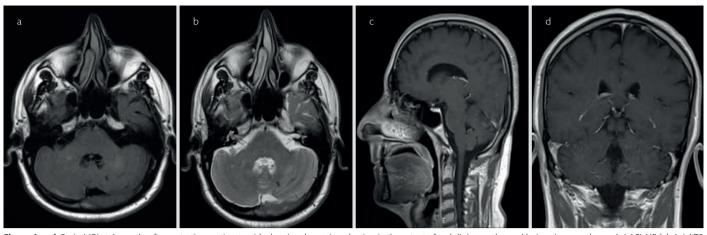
a-d. Brain MRI at 4 months after restarting corticosteroids showing dramatic reduction in the extent of gadolinium-enhanced lesions in second case. Axial FLAIR (a), Axial T2 (b), Sagittal postcontrast (c) and Coronal T1 post contrast (d) weighted MR images show the resolution of lesions
